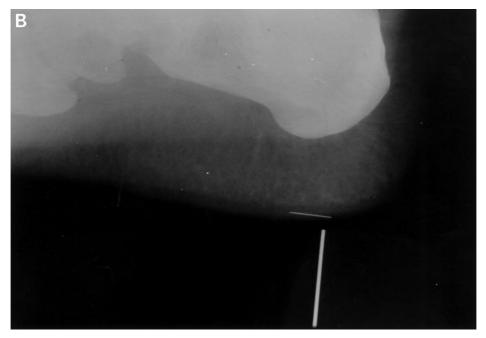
A 25-year-old girl with a sewing needle in her hand. (A) Radiograph of the hand; (B) on reviewing the medical charts, an old radiograph was found showing a sewing needle in the foot. On asking the family, it was discovered that she had undergone removal of sewing needles from various parts of her body on eight occasions during the previous 4 years. These procedures were performed at four different hospitals.
